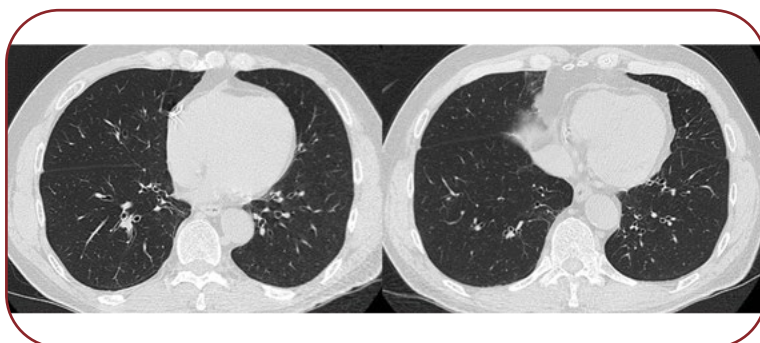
Chest CT taken 1.5 years after administration of dupilumab also showing disappearance of mucoid impactions, although bronchiectasis remained
